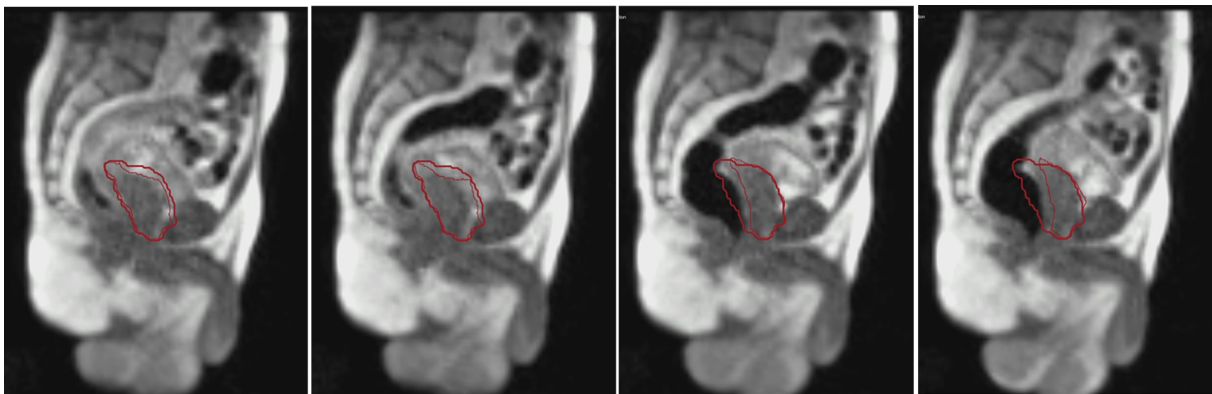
Intrafraction motion of the prostate. Sequential MRI images demonstrating intrafraction motion of the prostate due to rectal distention. The prostate position (thin red line) is compared against the planned treatment position (thick red line). Reprinted from Hegde et al.¹¹
